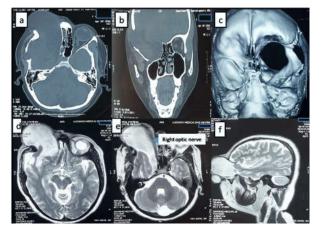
2 (a; b & c): NCCT with 3DCT – Complete aplasia of the right sphenoid wing with a right lateral orbital defect (Iatrogenic) with enlarged right orbital foramen, (d; e & f): MRI T2W1 shows giant orbital meningoencephalocoele. Dilated perisylvian cisterns and chiasmatic cisterns with inferiomedial displacement of right eye to the level of tip of nose with stretched right optic nerve.
